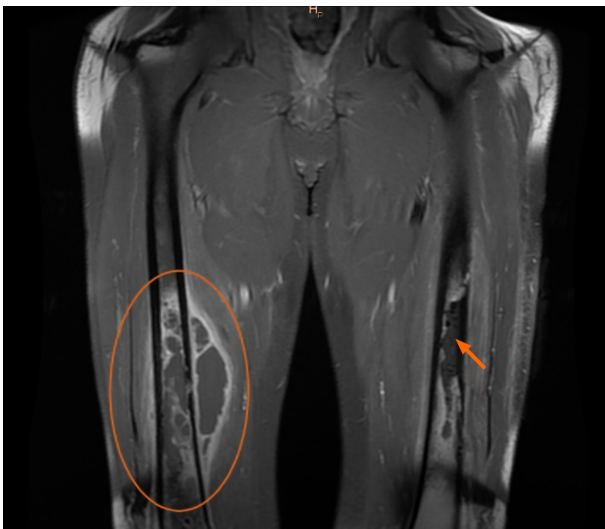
MRI scan of both thighs, frontal section. The orange circle shows the abscess near the femur and in intramedullary space. The orange arrow indicates the destructive processes taking place in the left femur. Also, the photo shows the longitudinal air inserts in the interfascial space.
